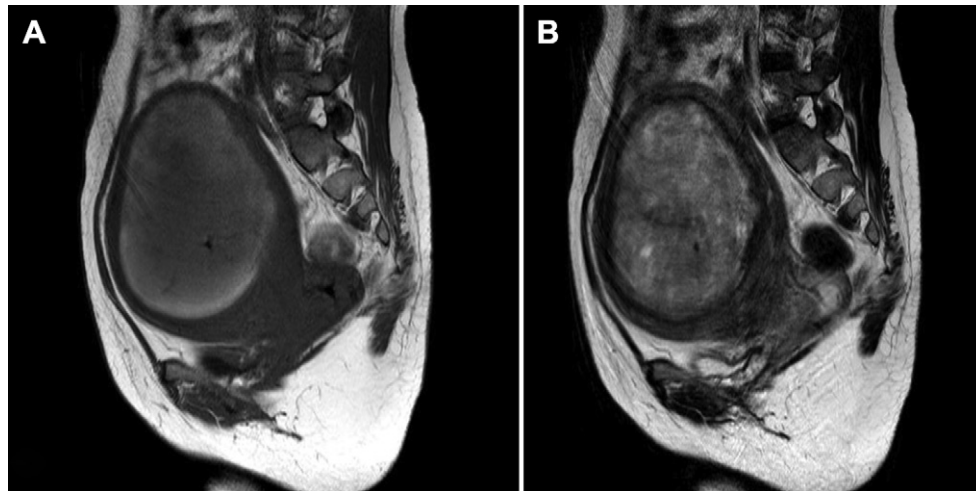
T1-weighted (A) and T2-weighted (B) images showing a 10 cm tumor on the anterior wall of the corpus of the uterus. An area of inhomogeneous high signal intensity is seen in the mass.
